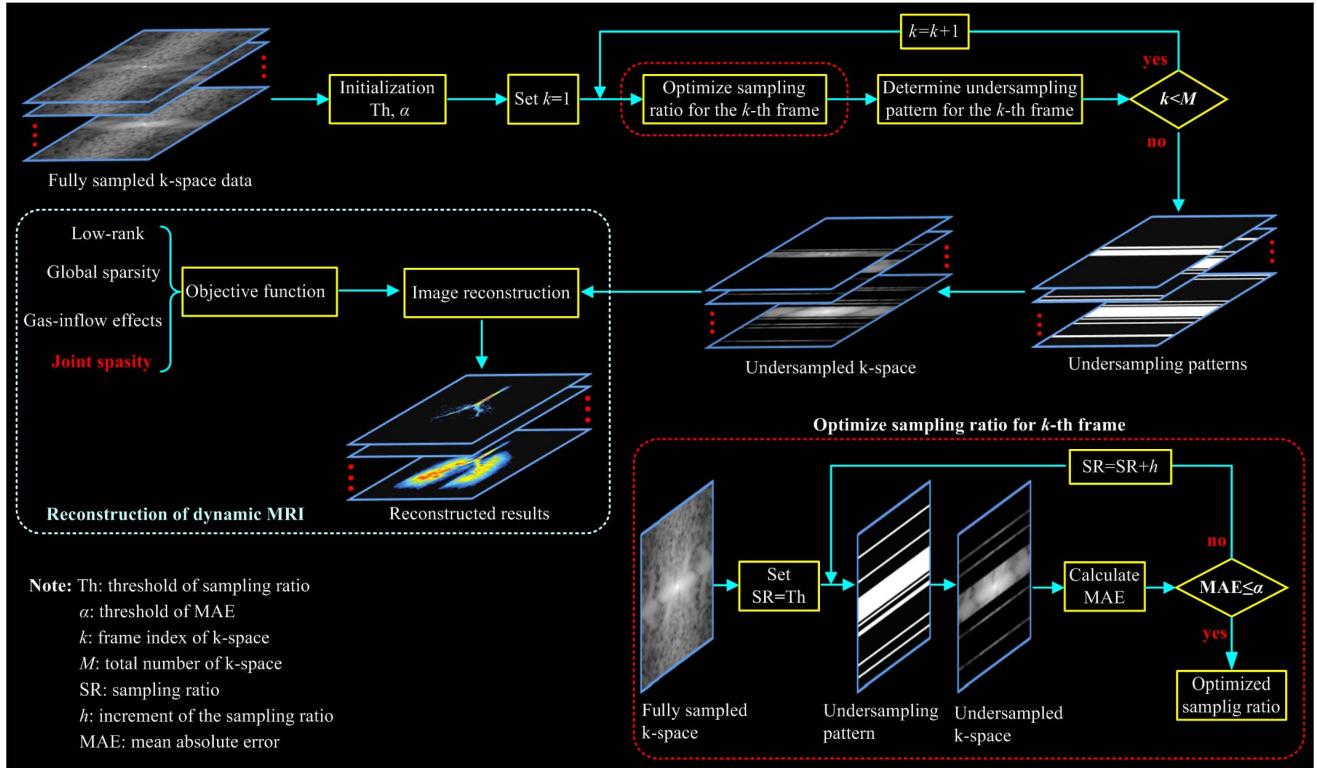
Framework of the proposed pulmonary HP  $^{129}\text{Xe}$  dynamic MRI, including two important steps. The first step is to adaptively undersample dynamic k-space data, and the second step is to effectively reconstruct dynamic images, considering the low-rank, global sparsity, gas-inflow effects, and joint sparsity constraints.
